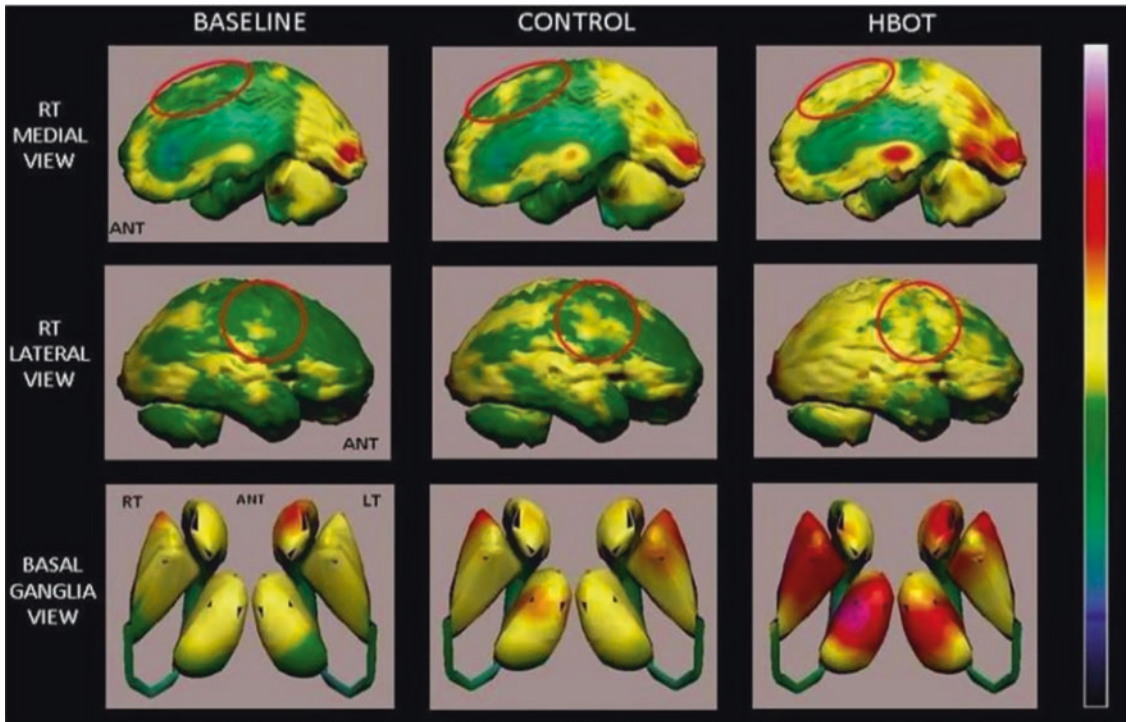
HBOT SPECT scan done at the end of HBOT treatments shows significant basal ganglia perfusion improvement. (Source: From [24] Efrati et al. (2013))
